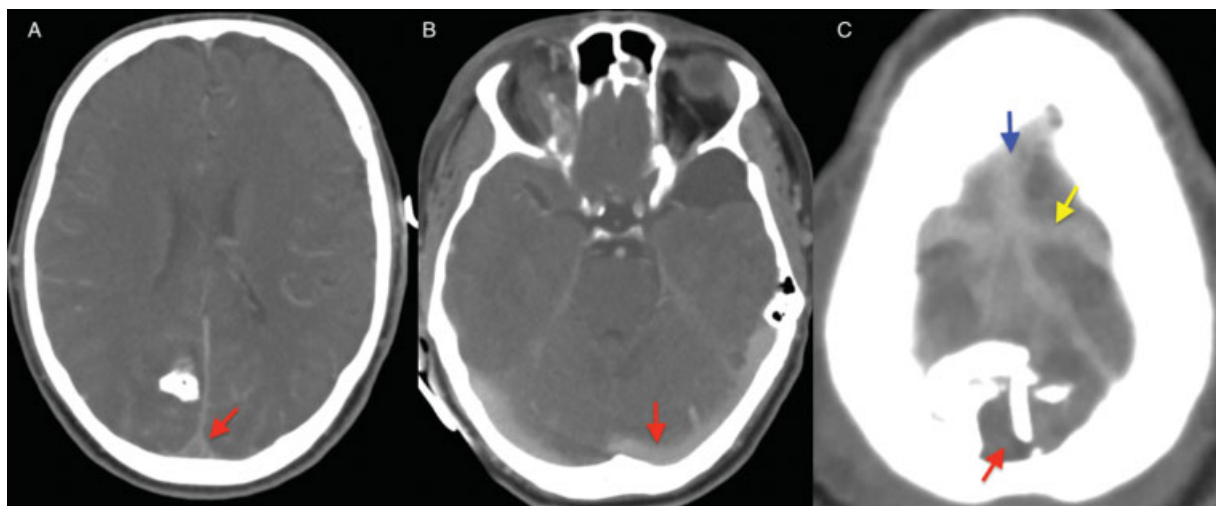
Preoperative axial computed tomography angiography (CTA). (A) “Empty delta sign” indicating Thrombosed sinus segment (*red arrow*). (B) Transverse sinus shows regular flow from collateral feeding veins. (C) Regular flow through rostral (*blue arrow*) and distal sinus segments (*red arrow*).
